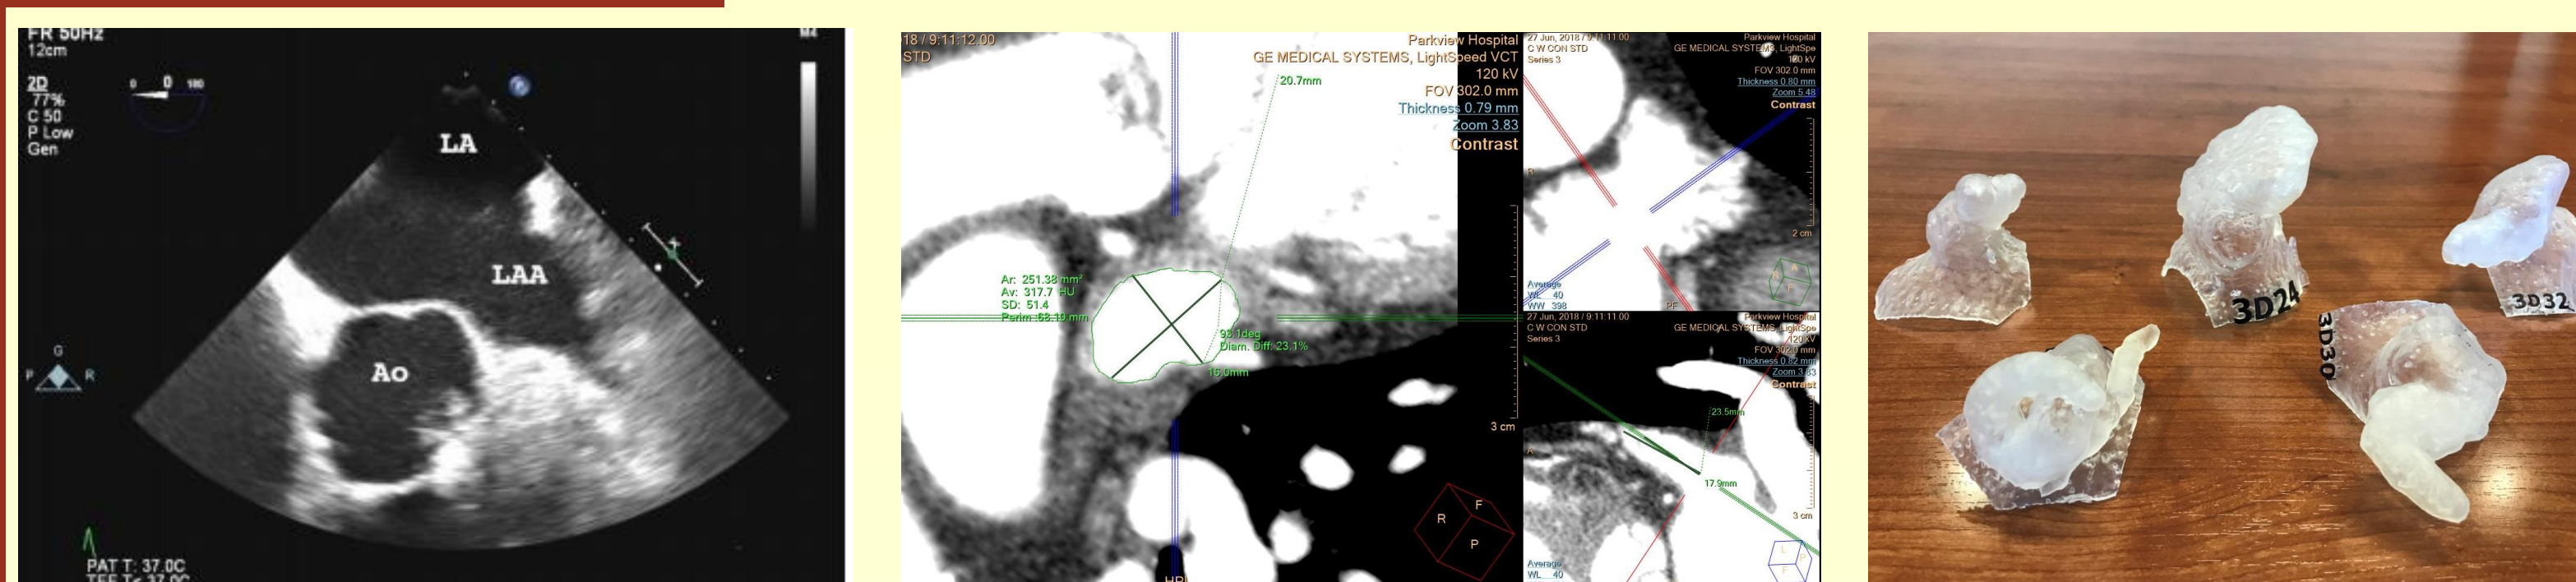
Imaging and modeling used for measuring the LAA (from left to right: TEE, CT, 3D models)
